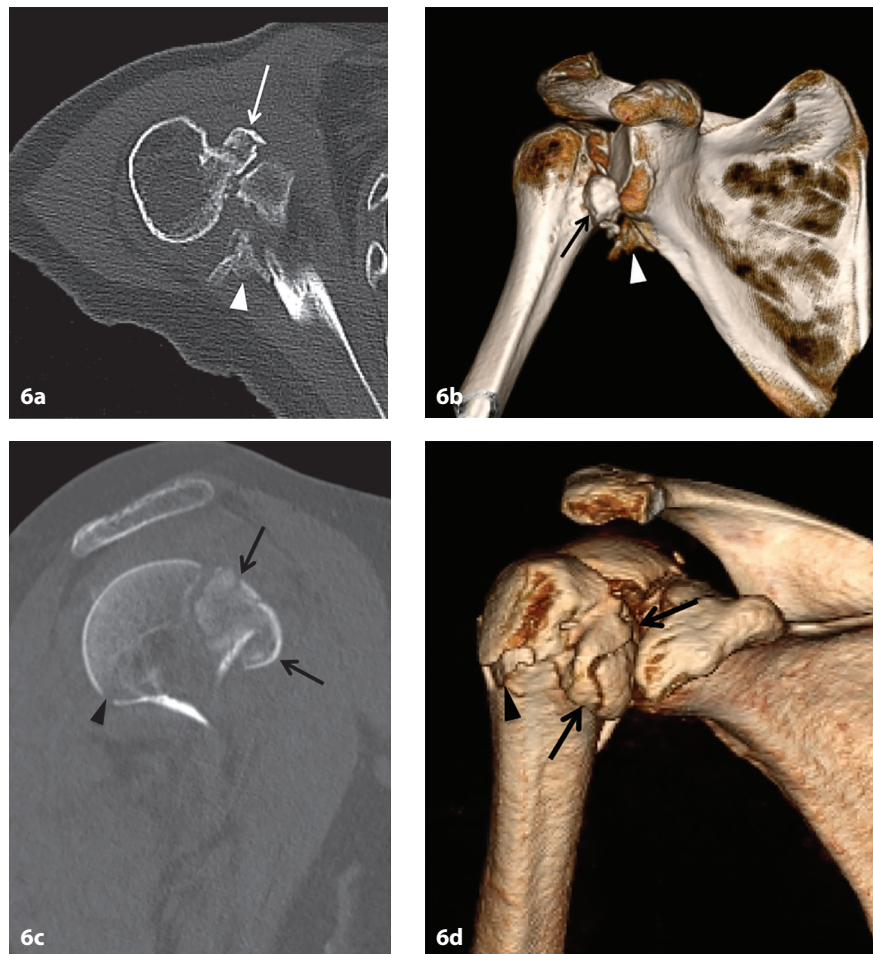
CT images of the “veil of obscuration” in the setting of posterior shoulder dislocations. (a) Axial and (b) 3D CT reconstruction images of the right shoulder clearly demonstrate a mildly displaced lesser tuberosity fracture fragment consistent with the “veil of obscuration” sign (arrow) and a displaced reverse bony Bankart lesion of the posterior glenoid (arrowhead). The humeral head is posteriorly subluxed. (c) Sagittal and (d) 3D CT reconstruction images of the right shoulder in another patient clearly demonstrate a mildly displaced comminuted lesser tuberosity fracture consistent with the “veil of obscuration” (arrows). Also note an associated comminuted humeral surgical neck fracture (arrowheads) as well as additional comminution of the humeral head. The humeral head is posteriorly subluxed, which was better seen on the axial CT images (not included).
